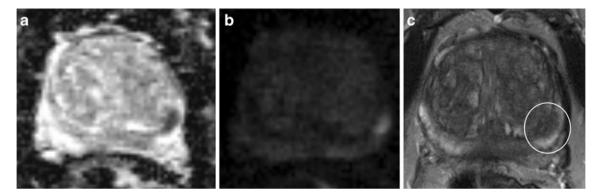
A 68-year-old patient with a small peripheral prostate cancer (Gleason Score 9) proved by MRI-guided in-bore biopsy. a Apparent diffusion coefficient (ADC) map with reduced signal intensity (SI); b
